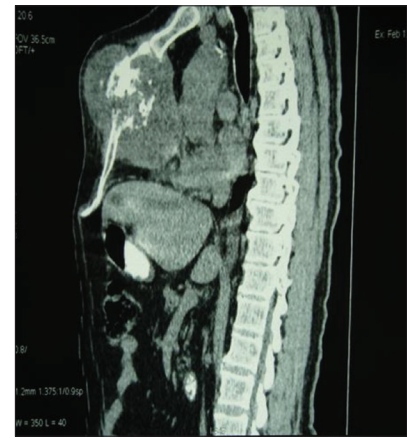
Preoperative chest computed tomography scan (sagittal view)
